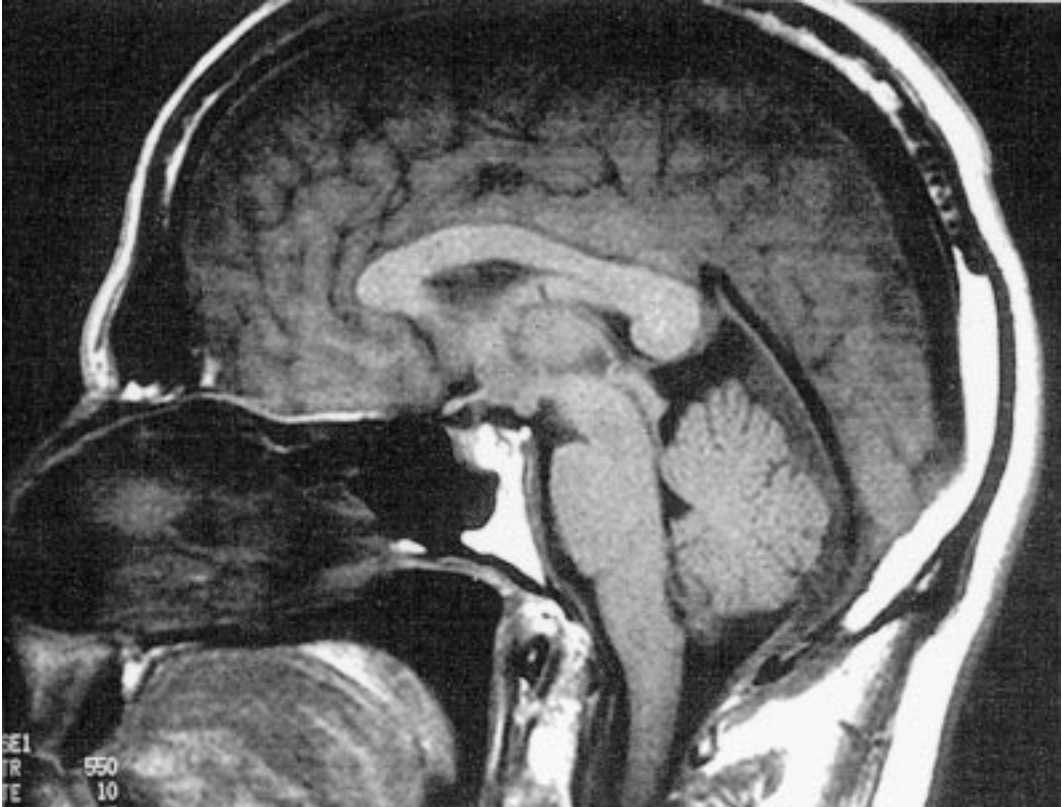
MRI of the brain shows a downwards displacement of the brainstem.
